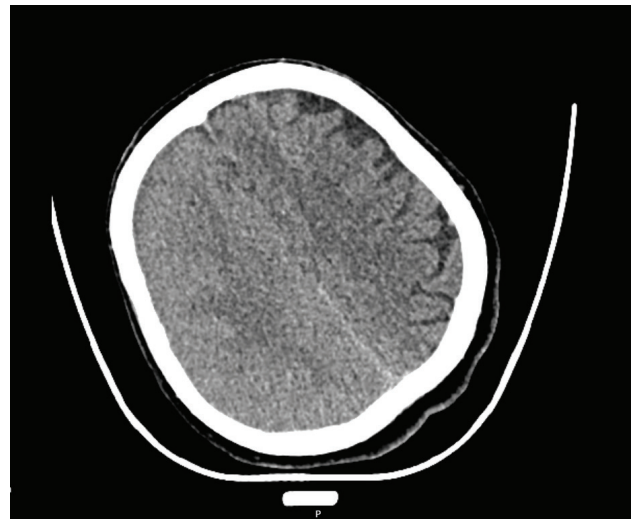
CT without contrast media.
